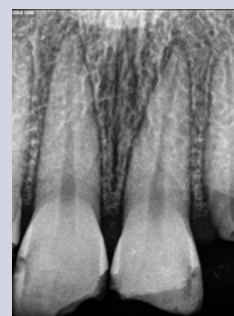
Periapical radiograph of teeth #8-9.
